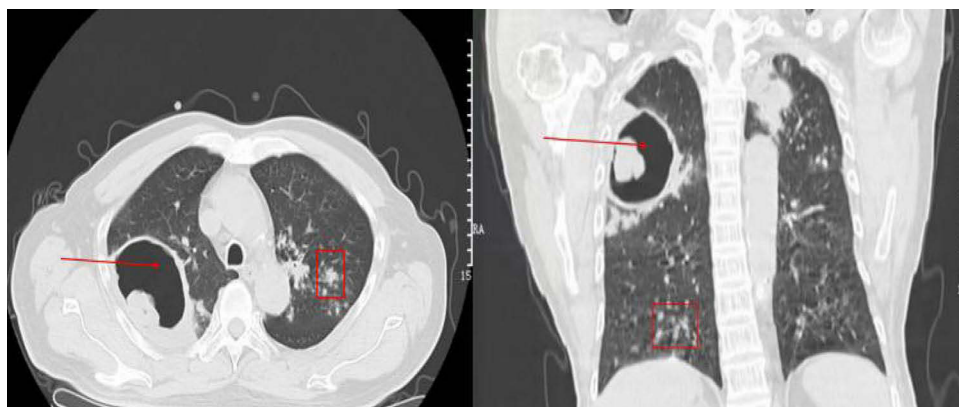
The chest CT scan revealed a symmetrical thorax with a centrally positioned trachea and increased bronchovascular bundles in both lungs. Speckled streaks and flaky densities were observed in multiple areas, including the apical posterior, lingular, dorsal lower lobe, and posterior basal segments of the left lung, as well as the apical, anterior, posterior, middle, dorsal, anterior, and medial basal segments of the right upper lobe of the right lung. These findings were accompanied by slightly blurred edges. Cavitation was noted in the apical posterior segment of the left lung and in the right lung, with larger cavitations particularly prominent in the right upper lung. (Red arrows indicate cavitation, while boxes highlight exudation.).
